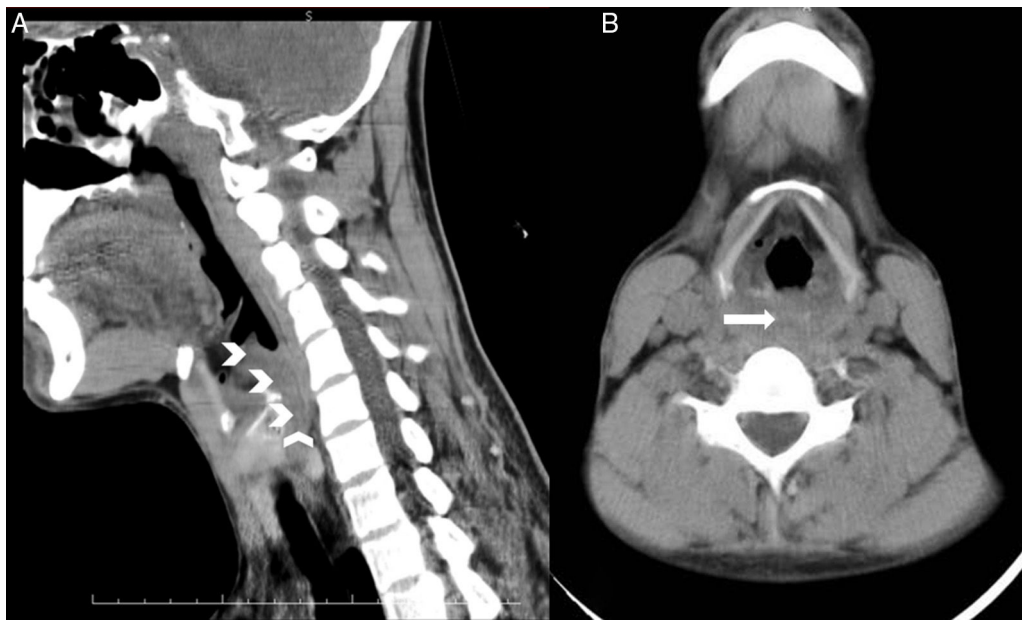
(A) Sagittal CT image showing a posterior transglottic laryngeal abscess (arrowheads). (B) Axial CT image showing abscess (arrow).
